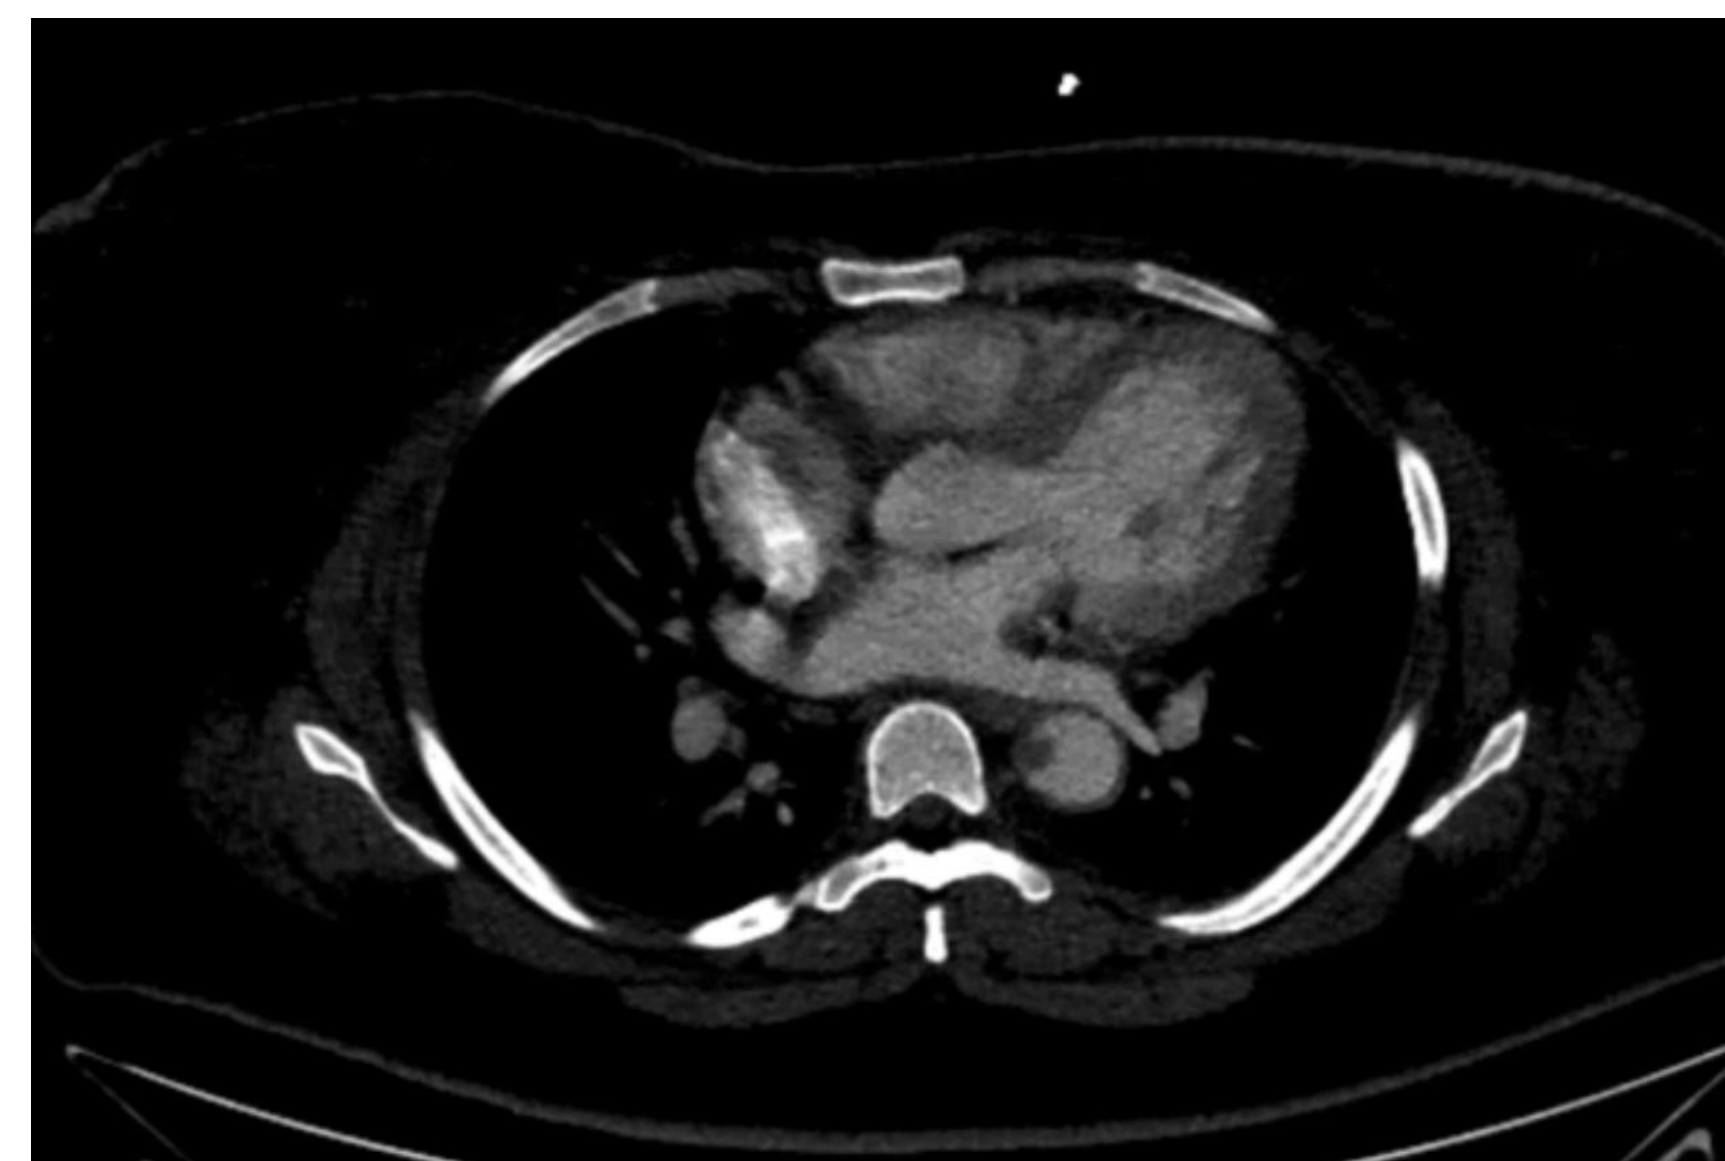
CT image demonstrating reaccumulation of aortic thrombus after failure of anticoagulation therapy. Fourth CT taken on 11/9/2020.
